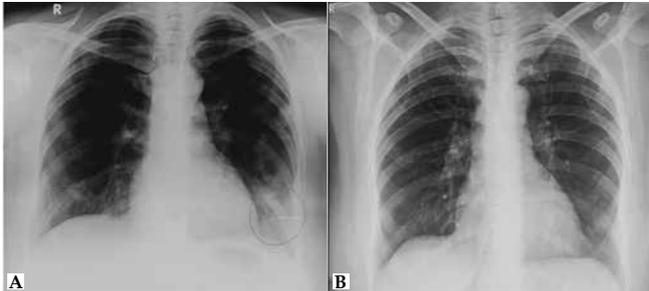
Patient 1 (Long COVID-ILD). Chest radiograph (postero-anterior view) showing (A) bilateral lower zone reticulations with ill-defined diaphragmatic and cardiac borders; and (B) resolution of the lower zone reticulations and clearing of diaphragmatic and cardiac borders after the treatment.
